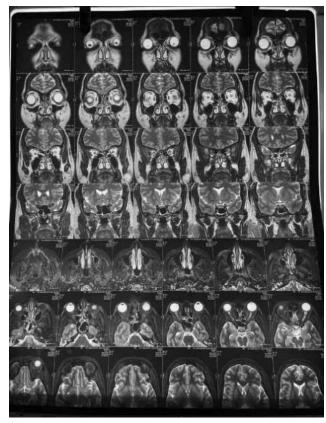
MRI brain showing left optic.
